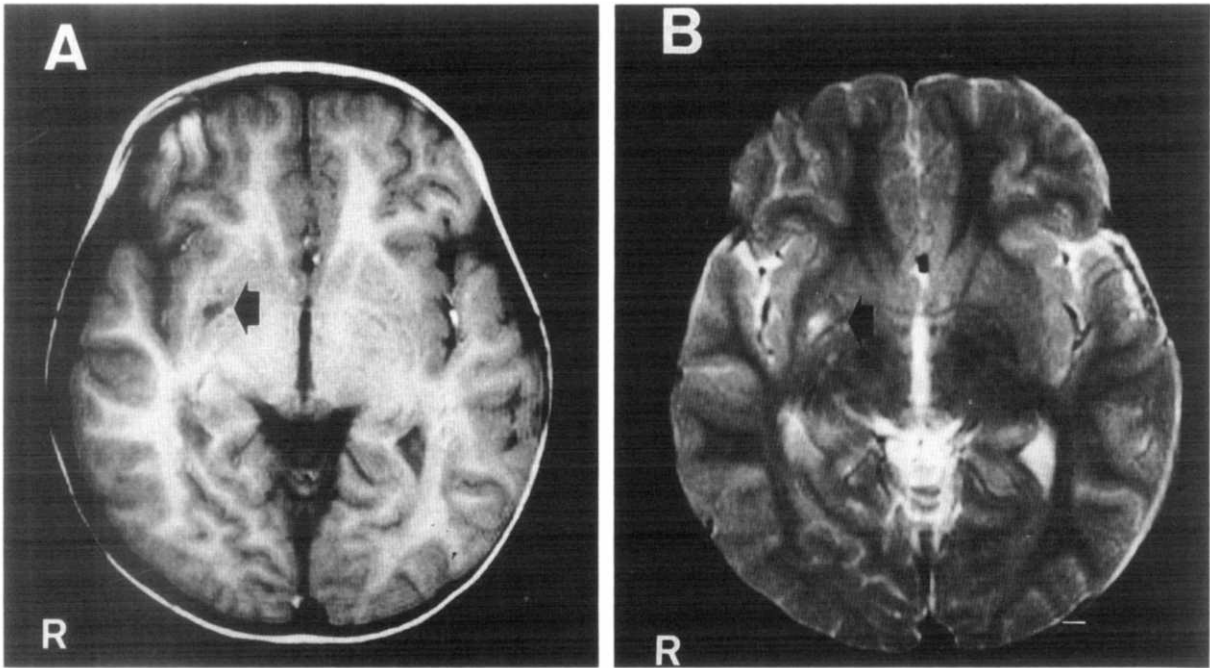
At the age of 6 years, MRI revealed a previous brain infarction in the right putamen (arrows). (A) T_1 -weighted spin echo axial view and (B) T_2 -weighted view.
